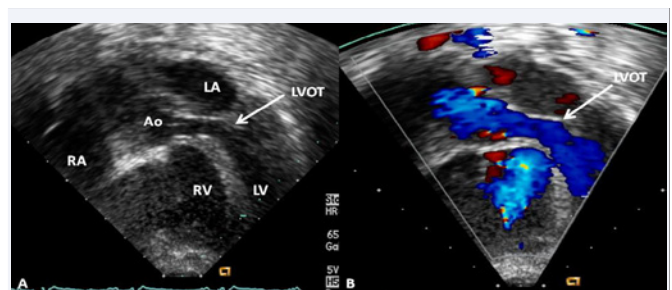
An apical five-chamber view of an echocardiogram showing a two-dimensional frame (A) and with color Doppler (B) showing the bulging of the right ventricle (RV) into the left ventricular outflow tract (LVOT). In this example, there is no significant obstruction; note the laminar flow in the LVOT and aorta (Ao). LA, left atrium; LV, left ventricle; RA, right atrium. Reproduced from Reference [12].
